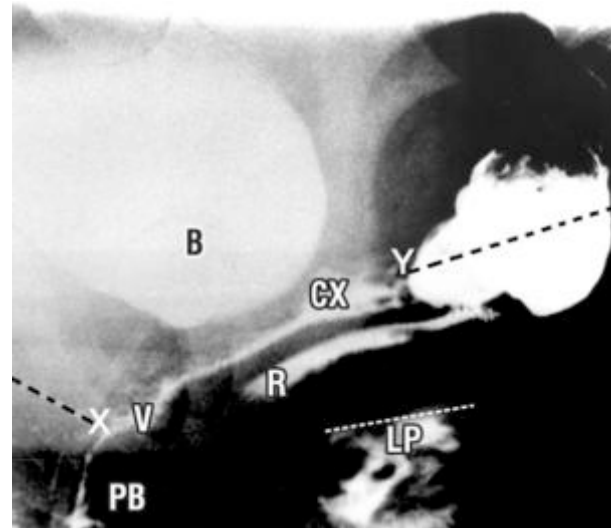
Patient continent of urine and feces. Sitting lateral X-Ray, with radio-opaque dye in bladder (B), vagina (V), rectum (R) and levator plate (LP). A white diagonal line represents the superior border of LP. PB = perineal body; R = rectum; CX = cervix; ‘X’ & ‘Y’ = insertion of the pubourethral and uterosacral ligaments (black broken lines).
